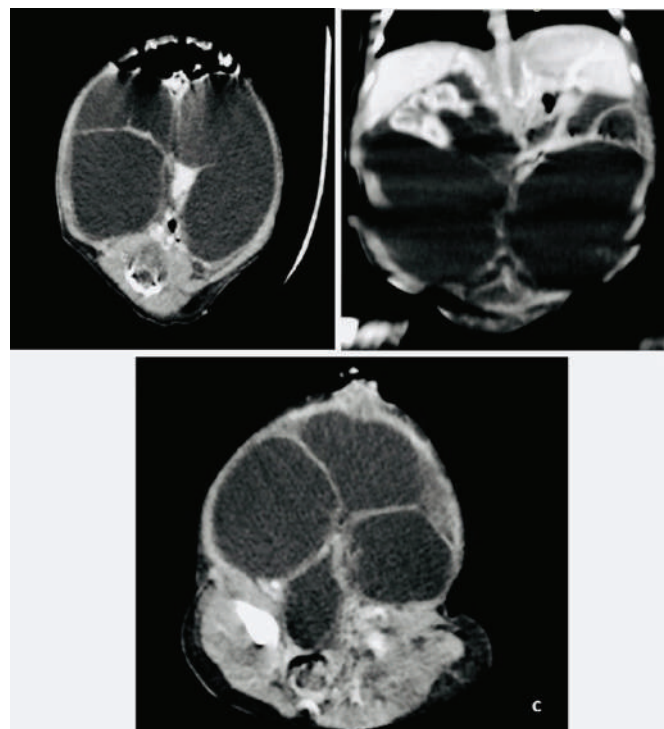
Contrast enhanced computed tomography findings (a) Large Cystic mass occupying the upper abdomen (b) large cystic lesion involving the entire abdomen and pelvis and causing compression of the right kidney (c) large cystic mass extending into the pelvis.
